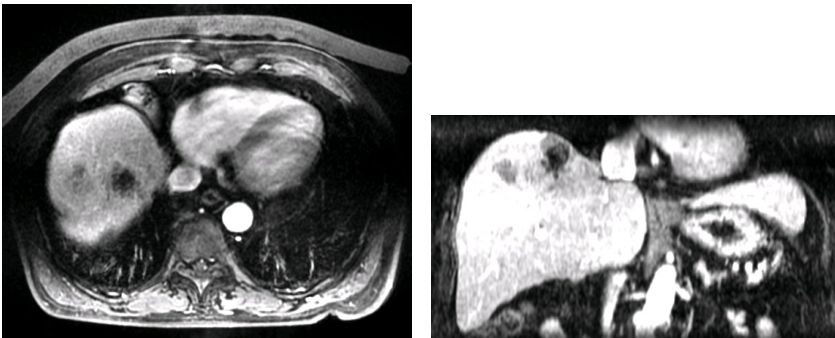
MRI images in transverse plane (left) and coronal plane (right)
